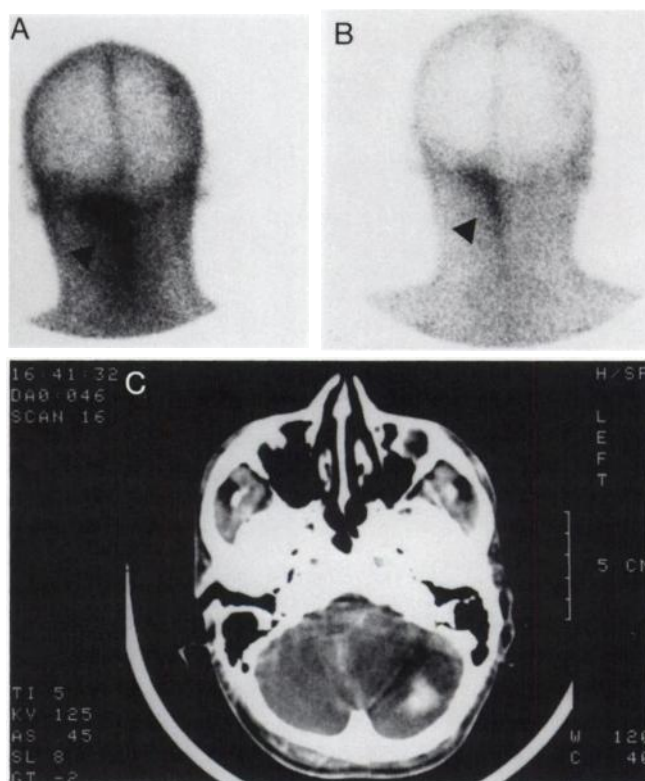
Cerebellar hemangioblastoma serendipitously detected by ^{99m}Tc -P280 in a patient with DVT. Posterior views of the skull acquired (A) 15 and (B) 240 min after peptide injection clearly indicate the lesion, subsequently confirmed by (C) CT.
